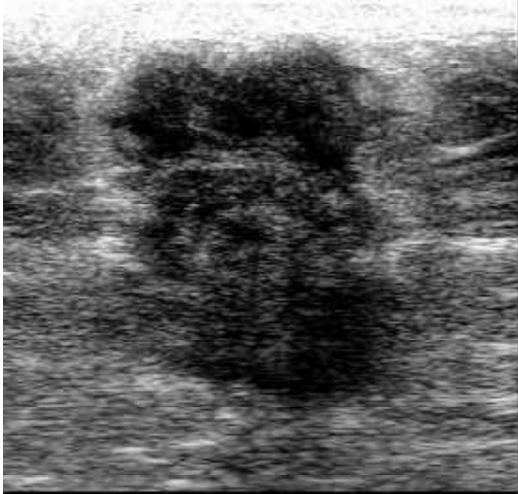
Targeted ultrasonography of left breast was performed utilizing an 11MHz transducer (Philips IE33). The retro areolar region of left breast shows an irregular, poorly marginated, hypoechoic lesion with angulated margins and showed posterior acoustic enhancement. No e/o any regional calcification was seen.
